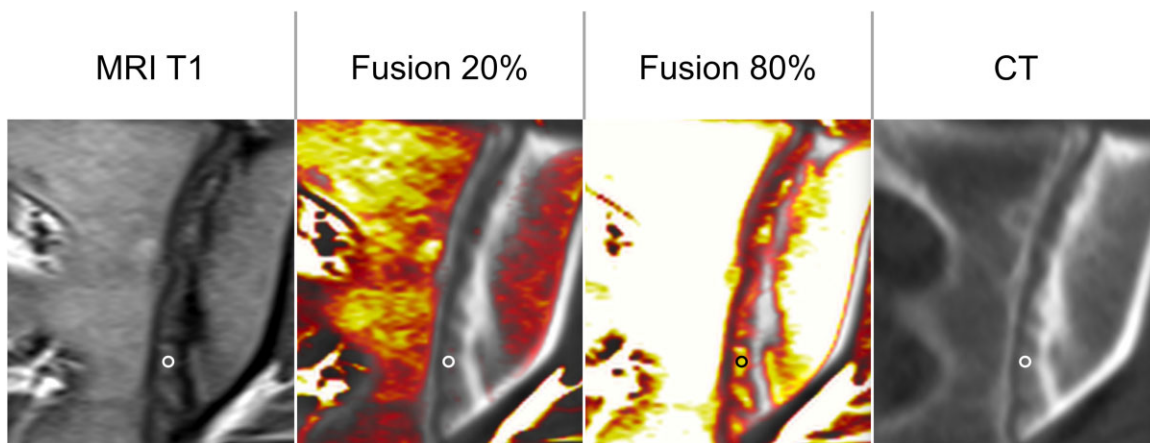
ROI with image fusion. To align MRI and CT scans, colour-coded fusion images were generated to identify the lesions visible in MRI on CT. The ROI was placed manually, avoiding partial volume to the normal cartilage, the bone and its margin and other lesions with different imaging characteristics
